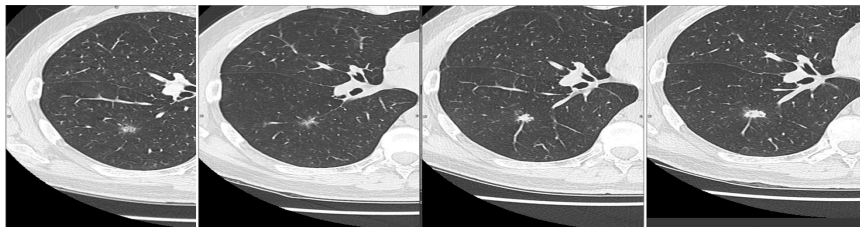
Patient 3: Four serial CT images spanning 917 days for atypical cells (arrow) highly suspicious for adenocarcinoma by biopsy.
